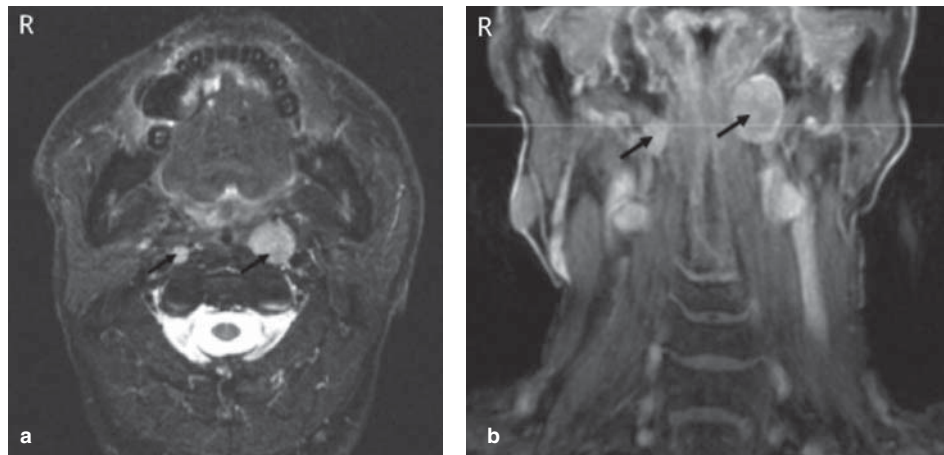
Case 1. MRI (Gd-DTPA) showing enhanced lymph node swelling in the bilateral lateral retropharyngeal space: (a) axial, T1-weighted; (b) coronal, T2-weighted. Arrows indicate retropharyngeal lymph node metastases.
